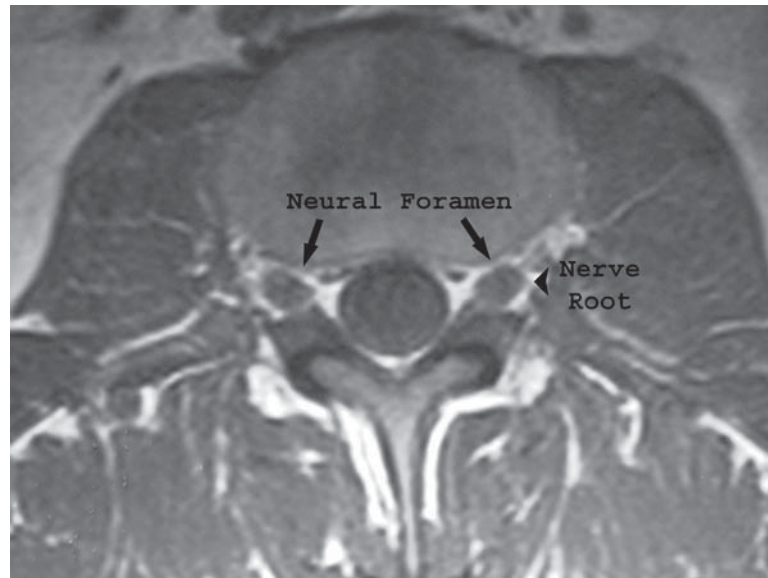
Axial T1 MRI showing the intervertebral (neural) foramen and nerve roots. It is easy to appreciate how a disc herniation can compress the exiting nerve root as it passes through the narrow confines of the intervertebral (neural) foramen.
